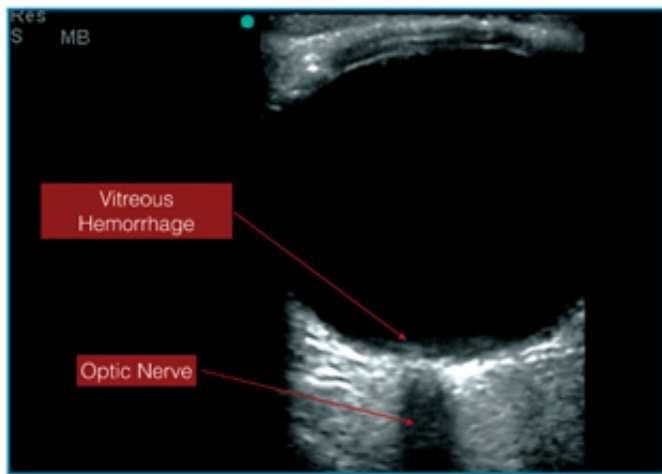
Ocular ultrasound showing small posterior vitreous hemorrhage, with increased gain.
